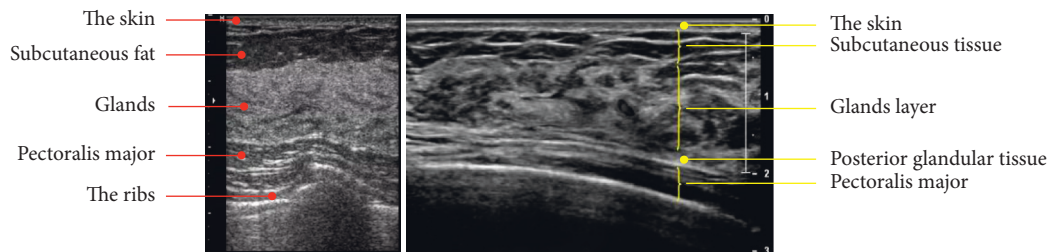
Comparison of ultrasound findings of healthy and diseased patients.
